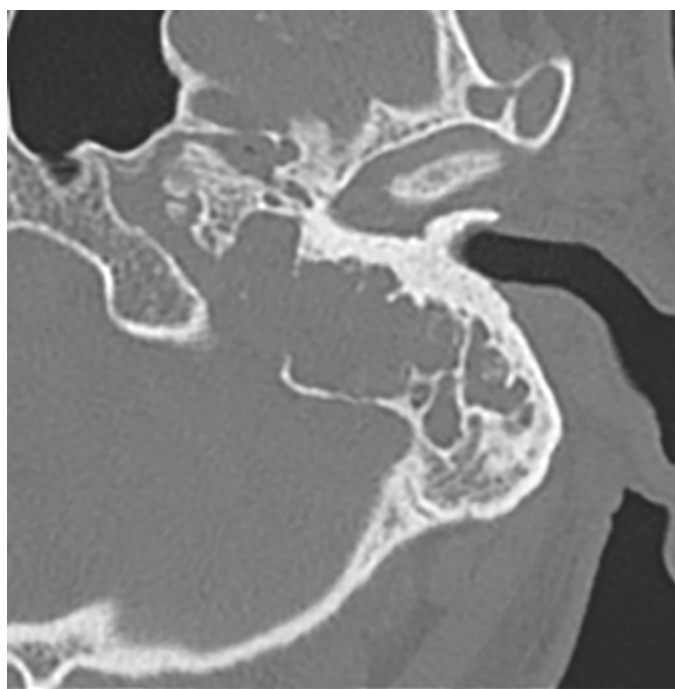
Axial bone CT image shows extensive bone destruction of the jugular fossa and mastoid with a soft tissue mass in the middle ear that surrounds the middle ear ossicles.
